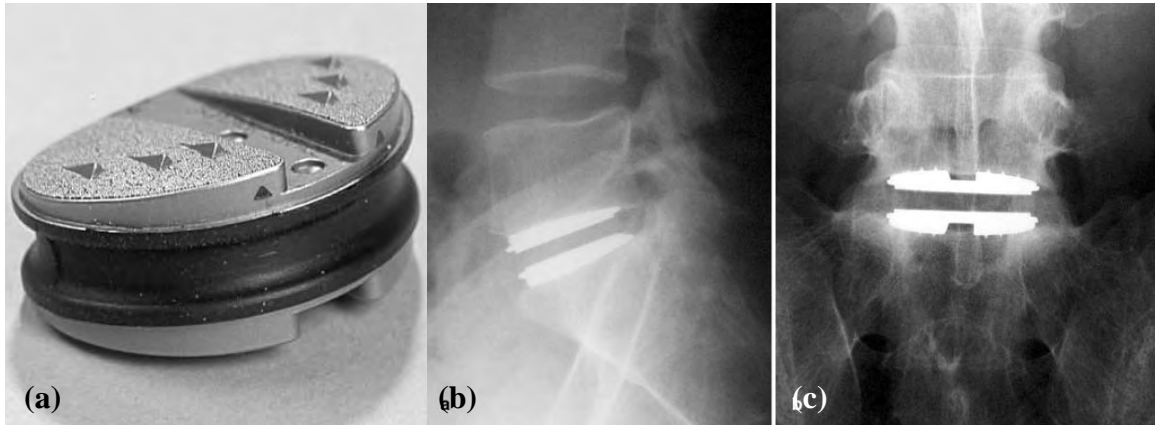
(a) Example of flexible disc prosthesis, the Acroflex artificial device, (b) postoperative lateral radiographic view with arthrodesis treatment on L4-L5, (c) postoperative anterior radiographic view [71]
